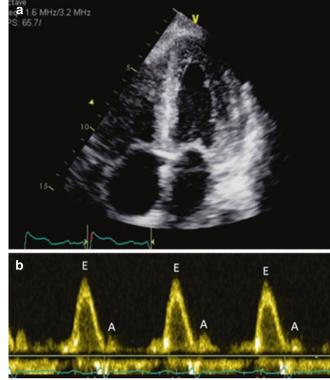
(a) Four chamber echocardiographic view in a patient with restrictive cardiomyopathy from cardiac amyloidosis. A thickened left ventricle with small LV cavity and enlarged atria are seen. (b) Transmitral flow showing a short mitral E deceleration time and low A velocity resulting in high E/A ratio, consistent with restrictive filling
